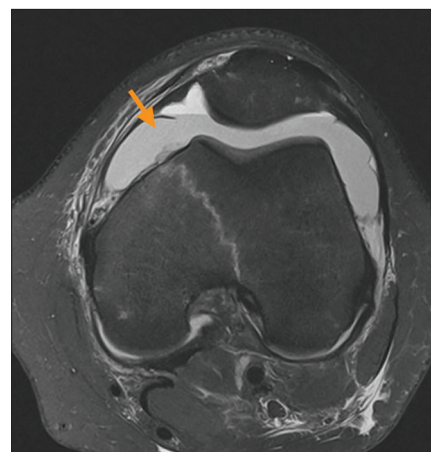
T2-weighted, fat-saturated magnetic resonance image axial view that shows a fracture (anterior to posterior from the medial femoral condyle) into the trochlear notch. Hemarthrosis is present (arrow).
